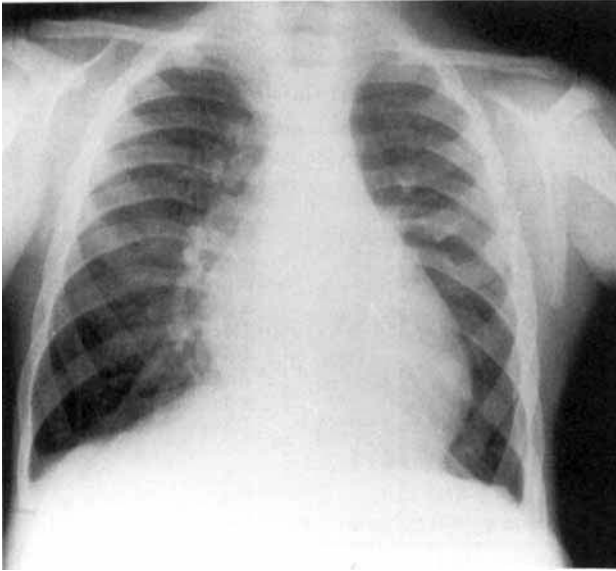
Chest radiograph showing cardiomegaly and wide ribs, age 2 years, 9 months.
